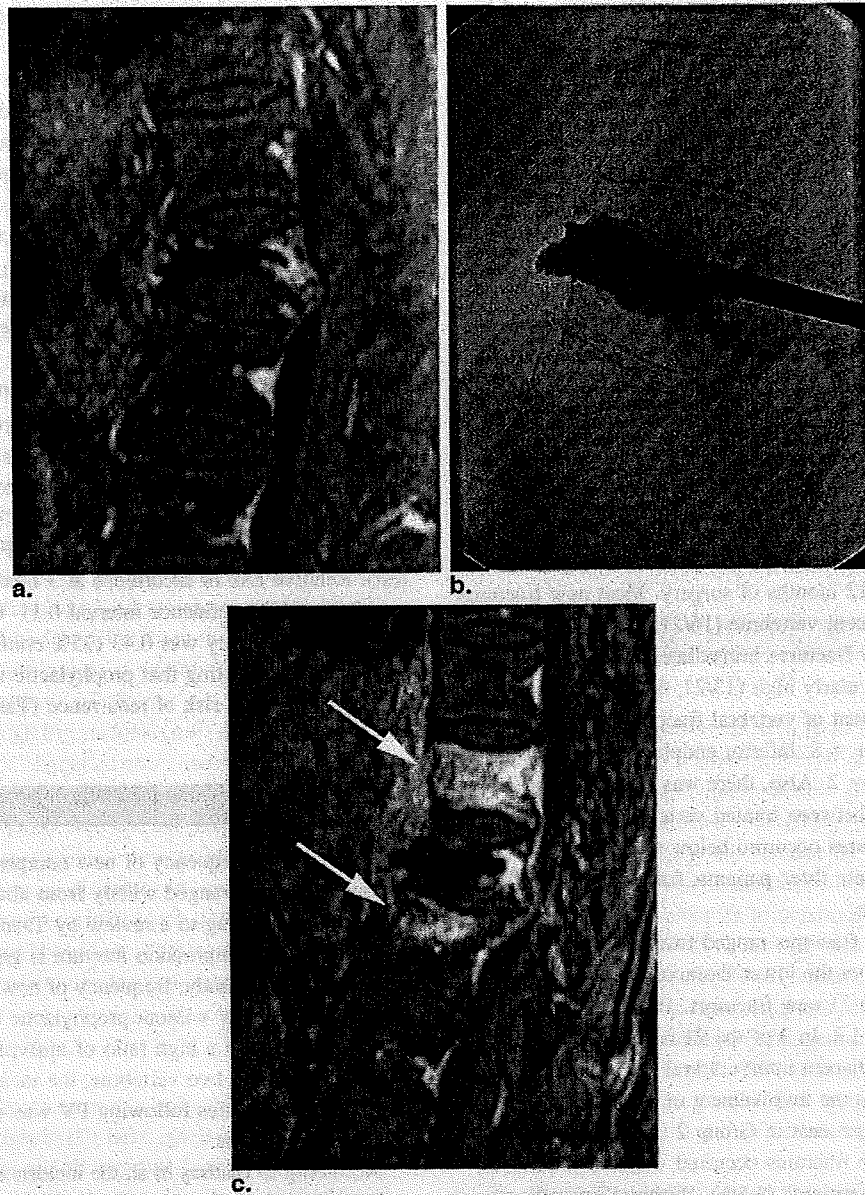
(a) Fat-suppressed contrast-enhanced T1-weighted sagittal image of a 78-year-old woman with osteoporotic compression fracture of the Th12 vertebra. (b) Cement was injected into the fractured vertebra. Fat-suppressed contrast-enhanced T1-weighted sagittal image. (c) Three weeks after percutaneous vertebroplasty, a new fracture developed in Th11 and L1 vertebrae. Bone marrow edema is seen throughout the entire vertebral body of Th11 and in the superior endplate of L1 (white arrows).
